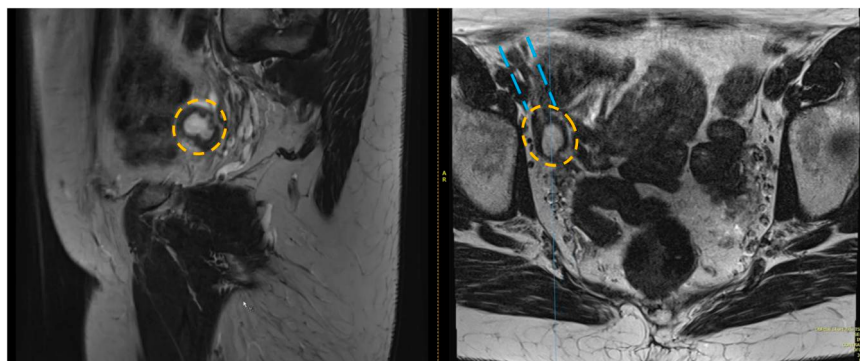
Preoperative magnetic resonance imaging of the pelvis demonstrating a cystic lesion (yellow dashed outline) arising from the right round ligament (blue dashed outline).
